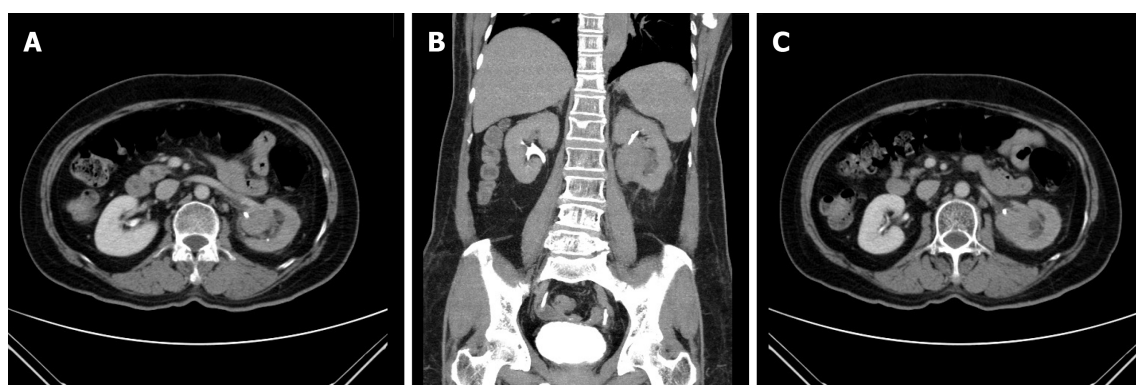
Computed tomography urogram. One 4.2 cm irregular mass was seen occupying the left renal pelvis on computed tomography urogram (A) (B); One enlarged lymph node was observed at the left renal pedicle (C).
